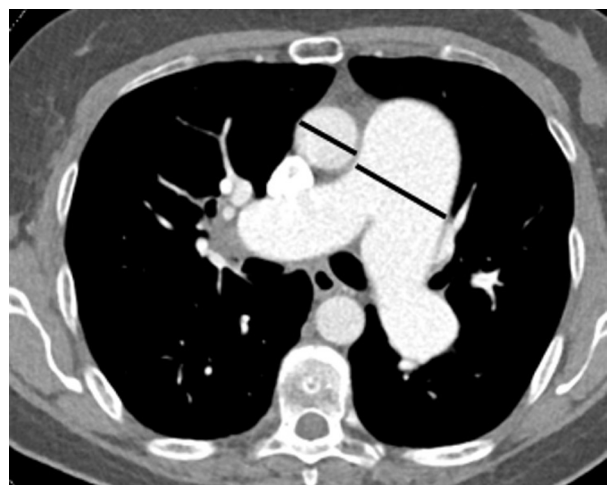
CT angiogram of the chest demonstrating a significantly enlarged pulmonary artery at the level of bifurcation with an increased pulmonary artery to aorta ratio $>1:1$ (black lines).
